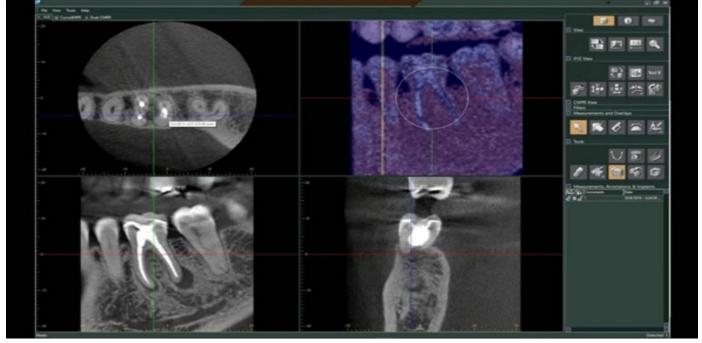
CBCT in endodontics
